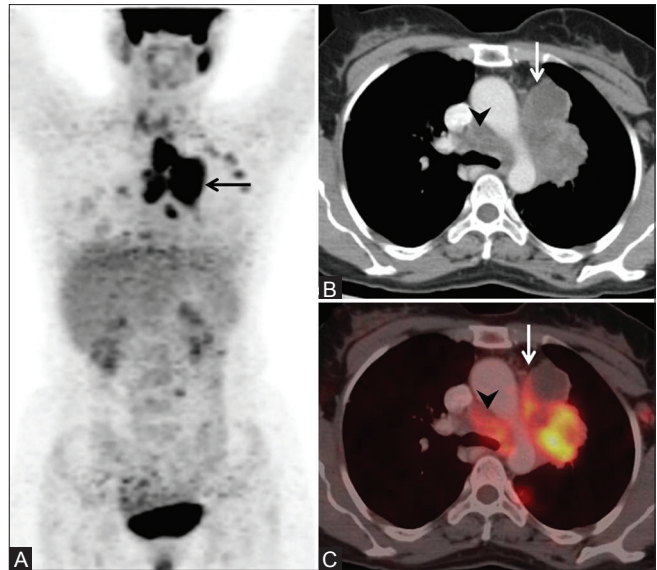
(A-C): Small cell lung cancer (limited stage). MIP image of an FDG PET study shows intense tracer concentration in the mediastinum (arrow, A) which corresponds to an FDG-avid soft tissue mass on CT and PET/CT (arrow in B and C) which extends into the mediastinum and appears to conglomerate and merge with the nodal disease (arrowheads, B). This is a typical radiological appearance of small cell cancers. No extrathoracic metastatic site is seen on the MIP image (A)
